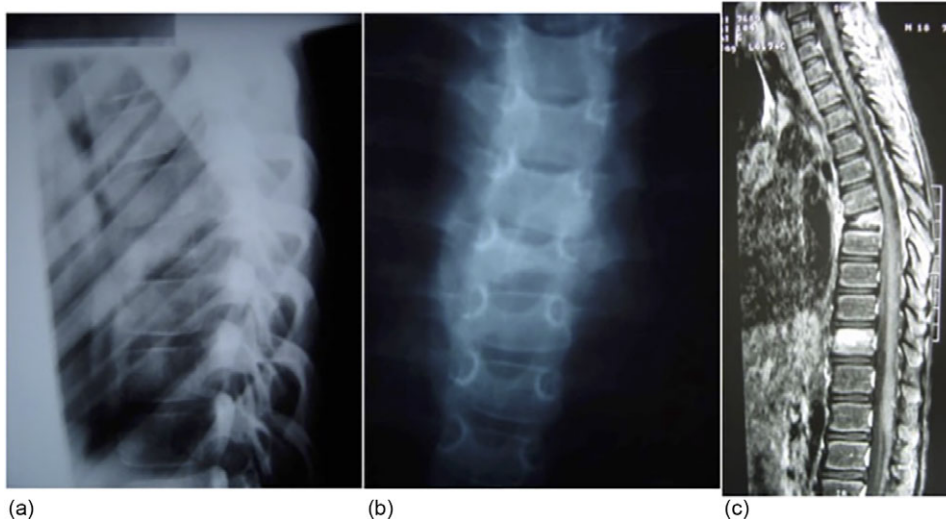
Plain imaging (a) lateral, (b) PA views and (c) sagittal T2 MRI image
